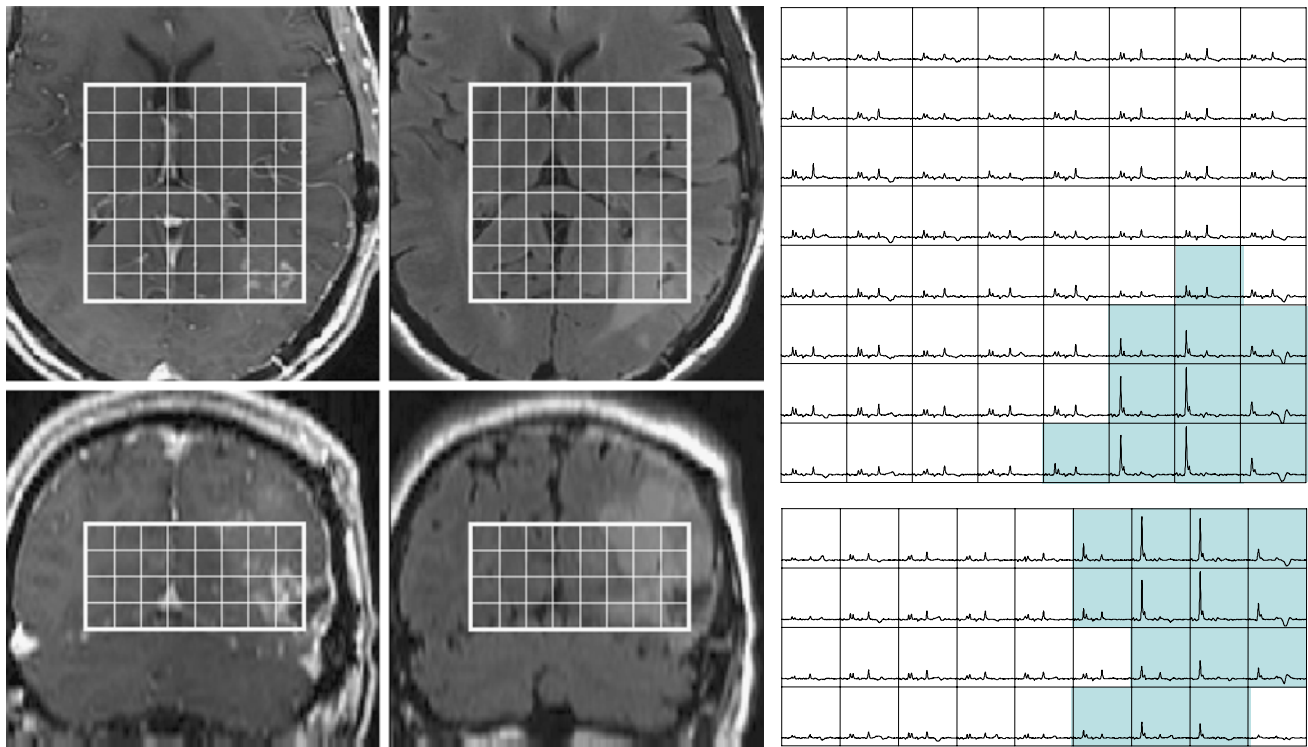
T1 post contrast and FLAIR images from a 49 year old patient with a newly diagnosed GBM whose lesion was classified as a gross total resection at the time of surgery. Four weeks later and immediately prior to treatment with radiation small regions of Gadolinium enhancement can be observed in the medial edge of the lesion and a more extensive area of hyperintensity on FLAIR images.
